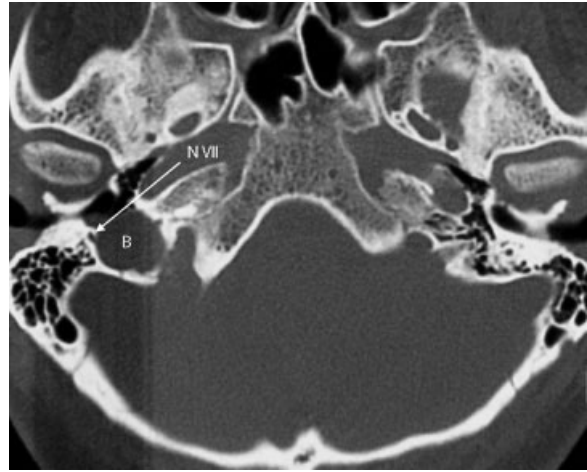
CT axial scan: high jugular bulb (B) protruding into tympanic cavity, with close contact to the mastoid segment of facial nerve (N VII).
